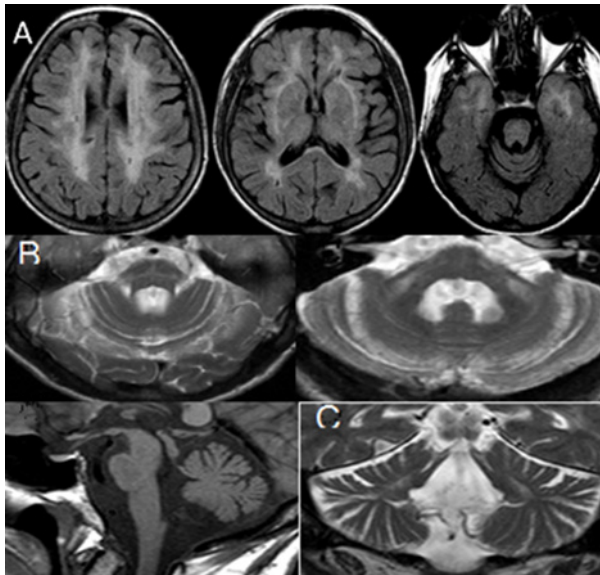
Skull MRI. A: cerebral volumetric reduction, extensive hypersignal area in periventricular white matter, frontoparietal subcortical; hypersignal in T2, with a cruciform aspect in the pons. B: Findings related to MSA with a cruciform-looking sign anomaly on the pons indicating degeneration of the transverse fibers and median raphe. Signal anomaly and atrophy of the middle cerebellar peduncles and moderate atrophy of the pons. C: Moderate atrophy of the cerebellar hemispheres, with widening of the grooves and compensatory dilation of the IV ventricle.
